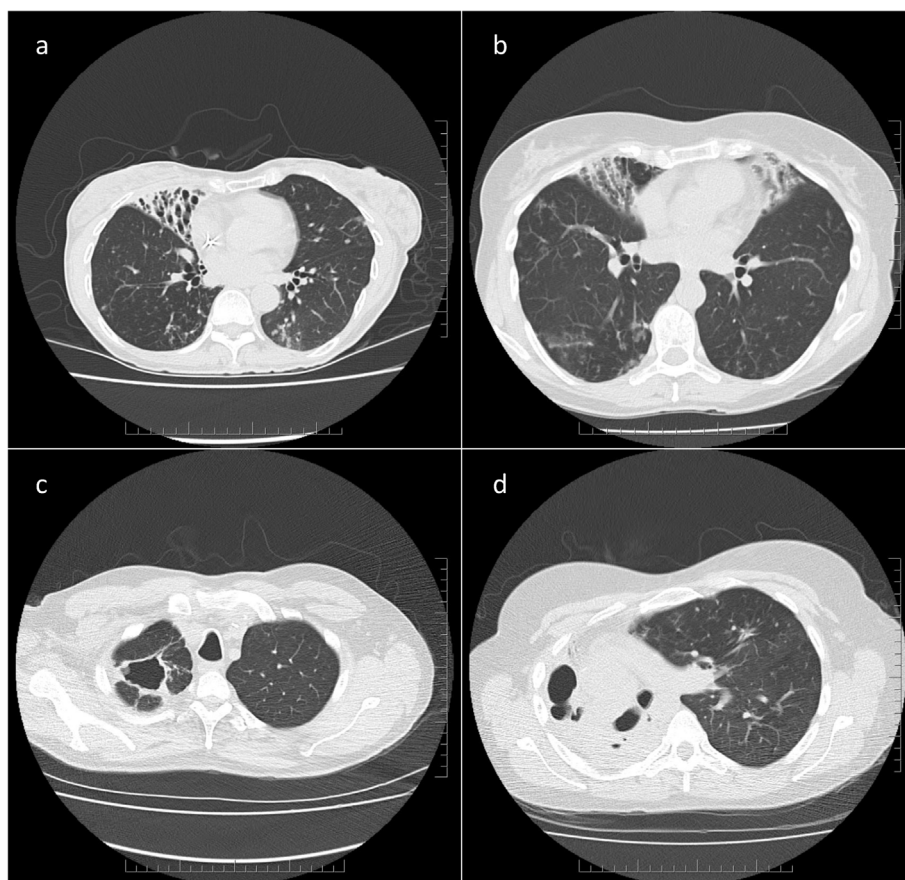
Most common radiographic patterns on CT scans.
